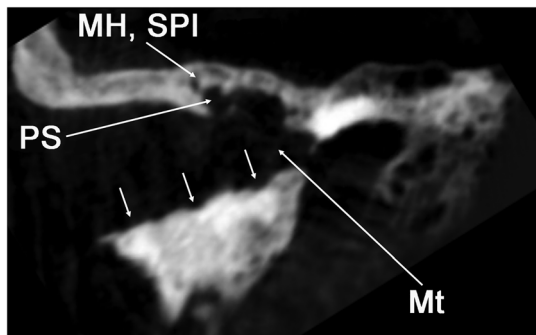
Coronal computed tomography (CT) of left temporal bone depict part of the ossicle chain in the epitympanum (MH, malleus head; SPI, short process of the incus), displaced cranially and laterally, near the tegmental wall. The middle ear and the external acoustic canal are widened (short arrows), although with scalloped contours. Mt, mesotympanus; PS, Prussak's space
